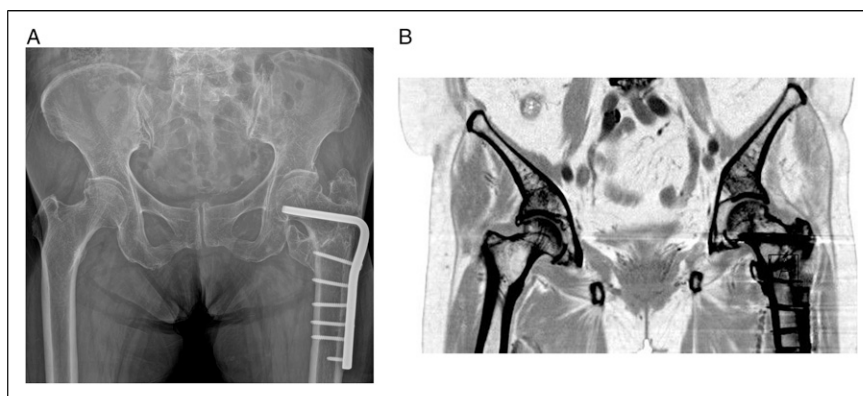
(A and B) Final follow-up X-ray showed solid union of the fracture site without neck shaft angle change.
